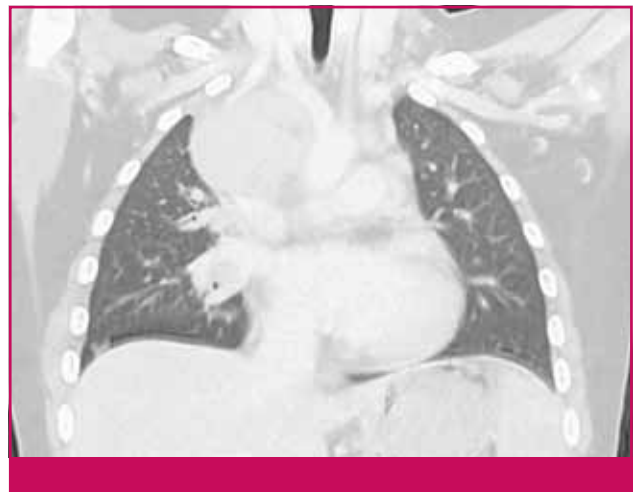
Chest CT scan revealing a mediastinal mass.
